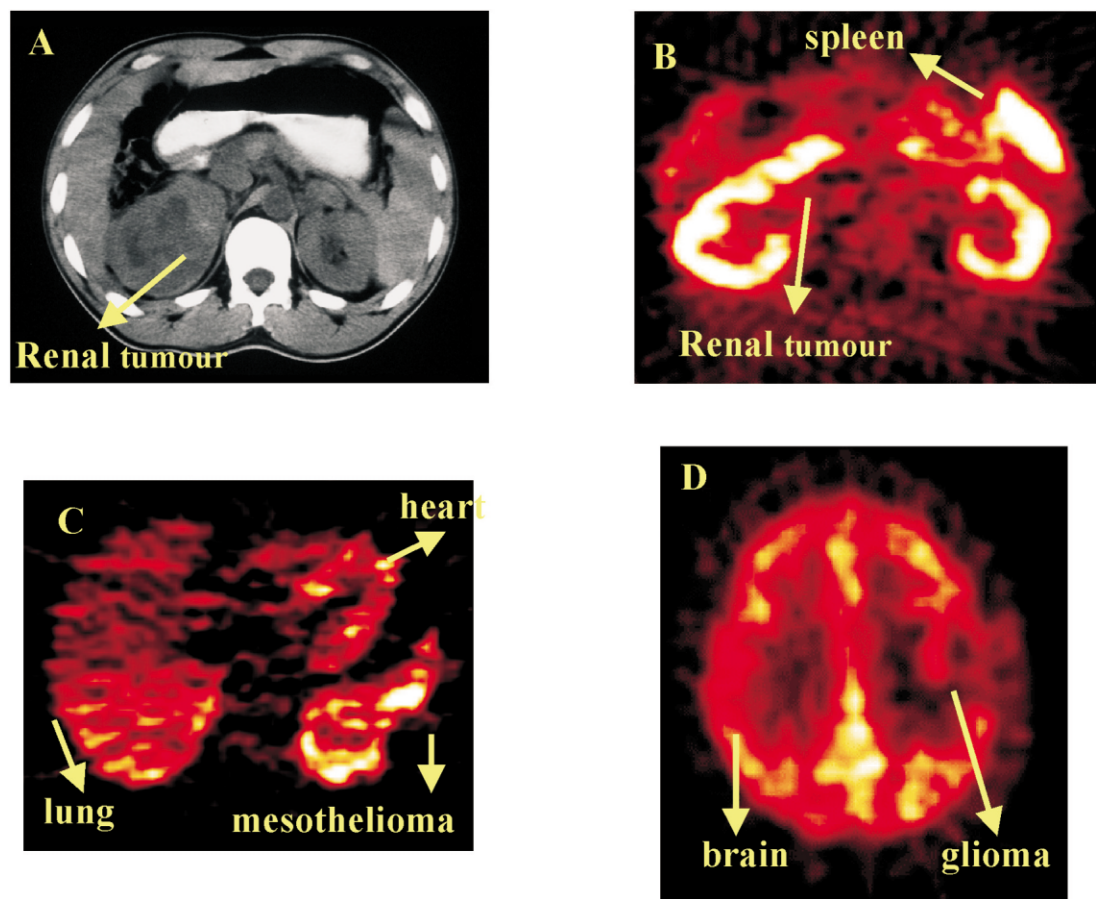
Transaxial abdominal Computed Tomography (CT) scan (top left) and corresponding Positron Emission Tomography (PET)-[<sup>11</sup>C]N-[2-(dimethylamino)-ethyl]acridine-4-carboxamide] (DACA) image (top right) demonstrating radiotracer uptake in kidneys, spleen and renal tumour. Uptake of radiotracer is seen in heart, and mesothelioma (bottom left) and brain and glioma (bottom right). Reproduced with permission from Lippincott Williams & Wilkins (*J Clin Oncol* 2001, 19(5), 1424, Fig. 2)
